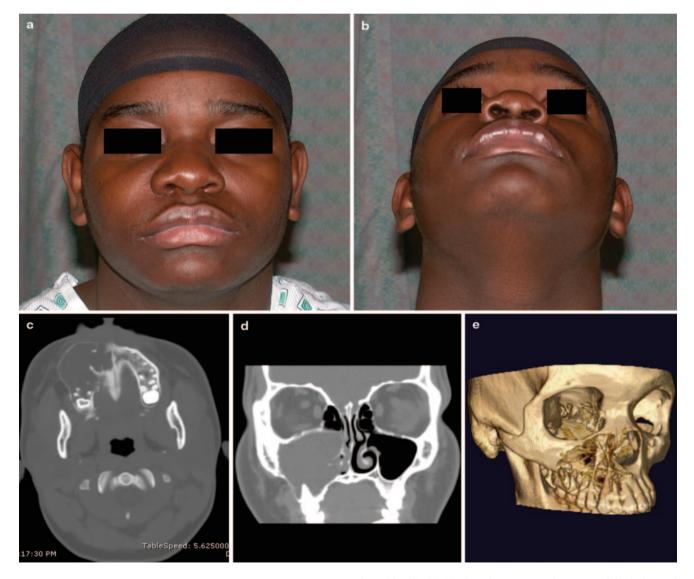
Seventeen-year-old male who presented with swelling on the right side of his face (a, b). An axial (c) and coronal (d) computed tomogram demonstrate an expansile mass obliterating the right maxillary
